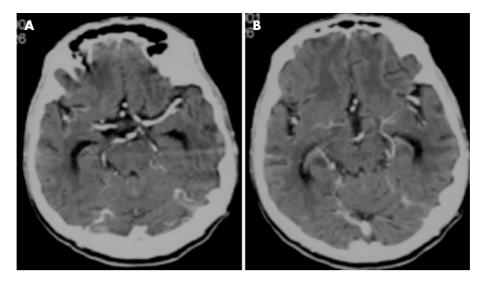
(A, B). Plain and contrast CT of a 63-year-old man at the level of the basal cisterns showing absence of any enhancing exudates in the cisterns. Mild dilatation of the temporal horns and third ventricle are noted.
